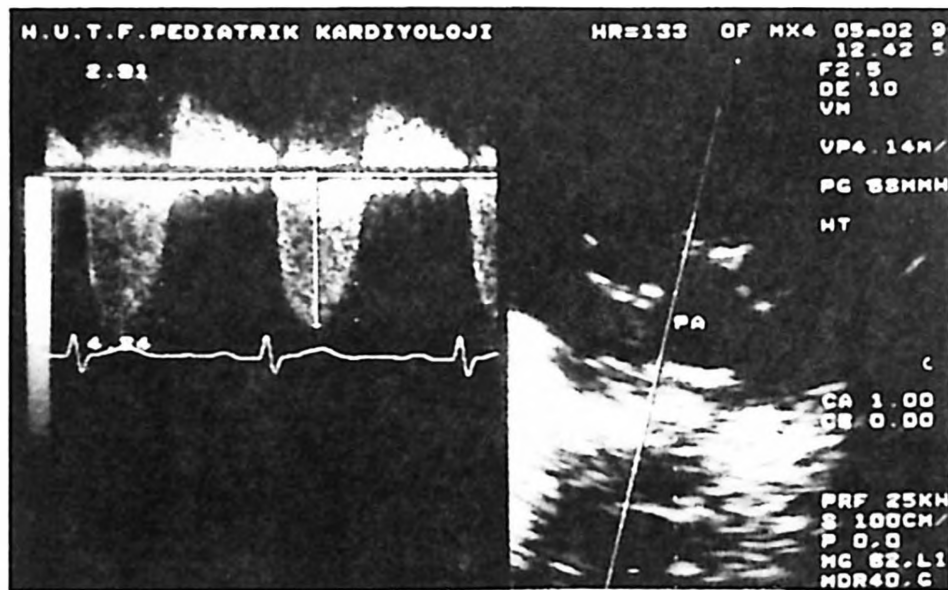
Same patient. Two-dimensional and continuous-wave Doppler echocardiogram in the parasternal short-axis view showing antegrade systolic flow (below the baseline) and retrograde diastolic flow (above the baseline) in the main pulmonary artery.
